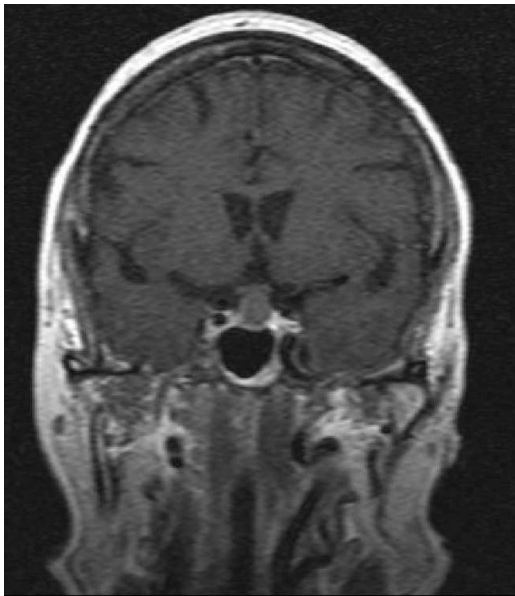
Preoperative MRI. Colloid cyst of sellar region that extend up to the optic chiasma
